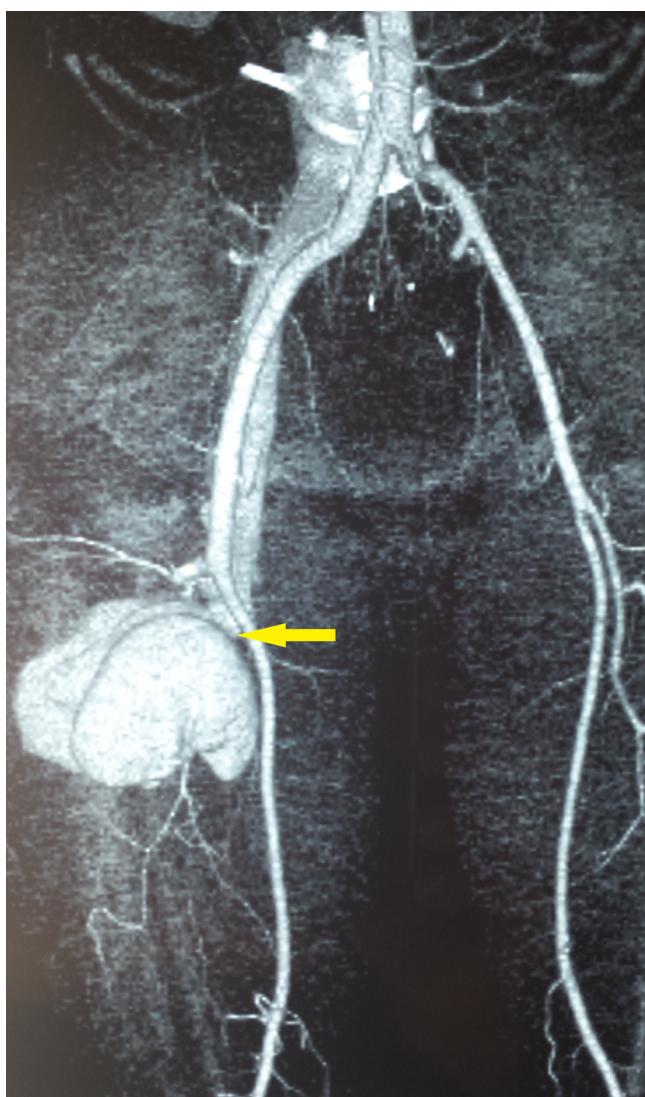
Computed tomography angiogram of the lower limbs showing a pseudoaneurysm of the second perforating branch of the DFA with femoro-femoral arteriovenous fistula (arrow).
